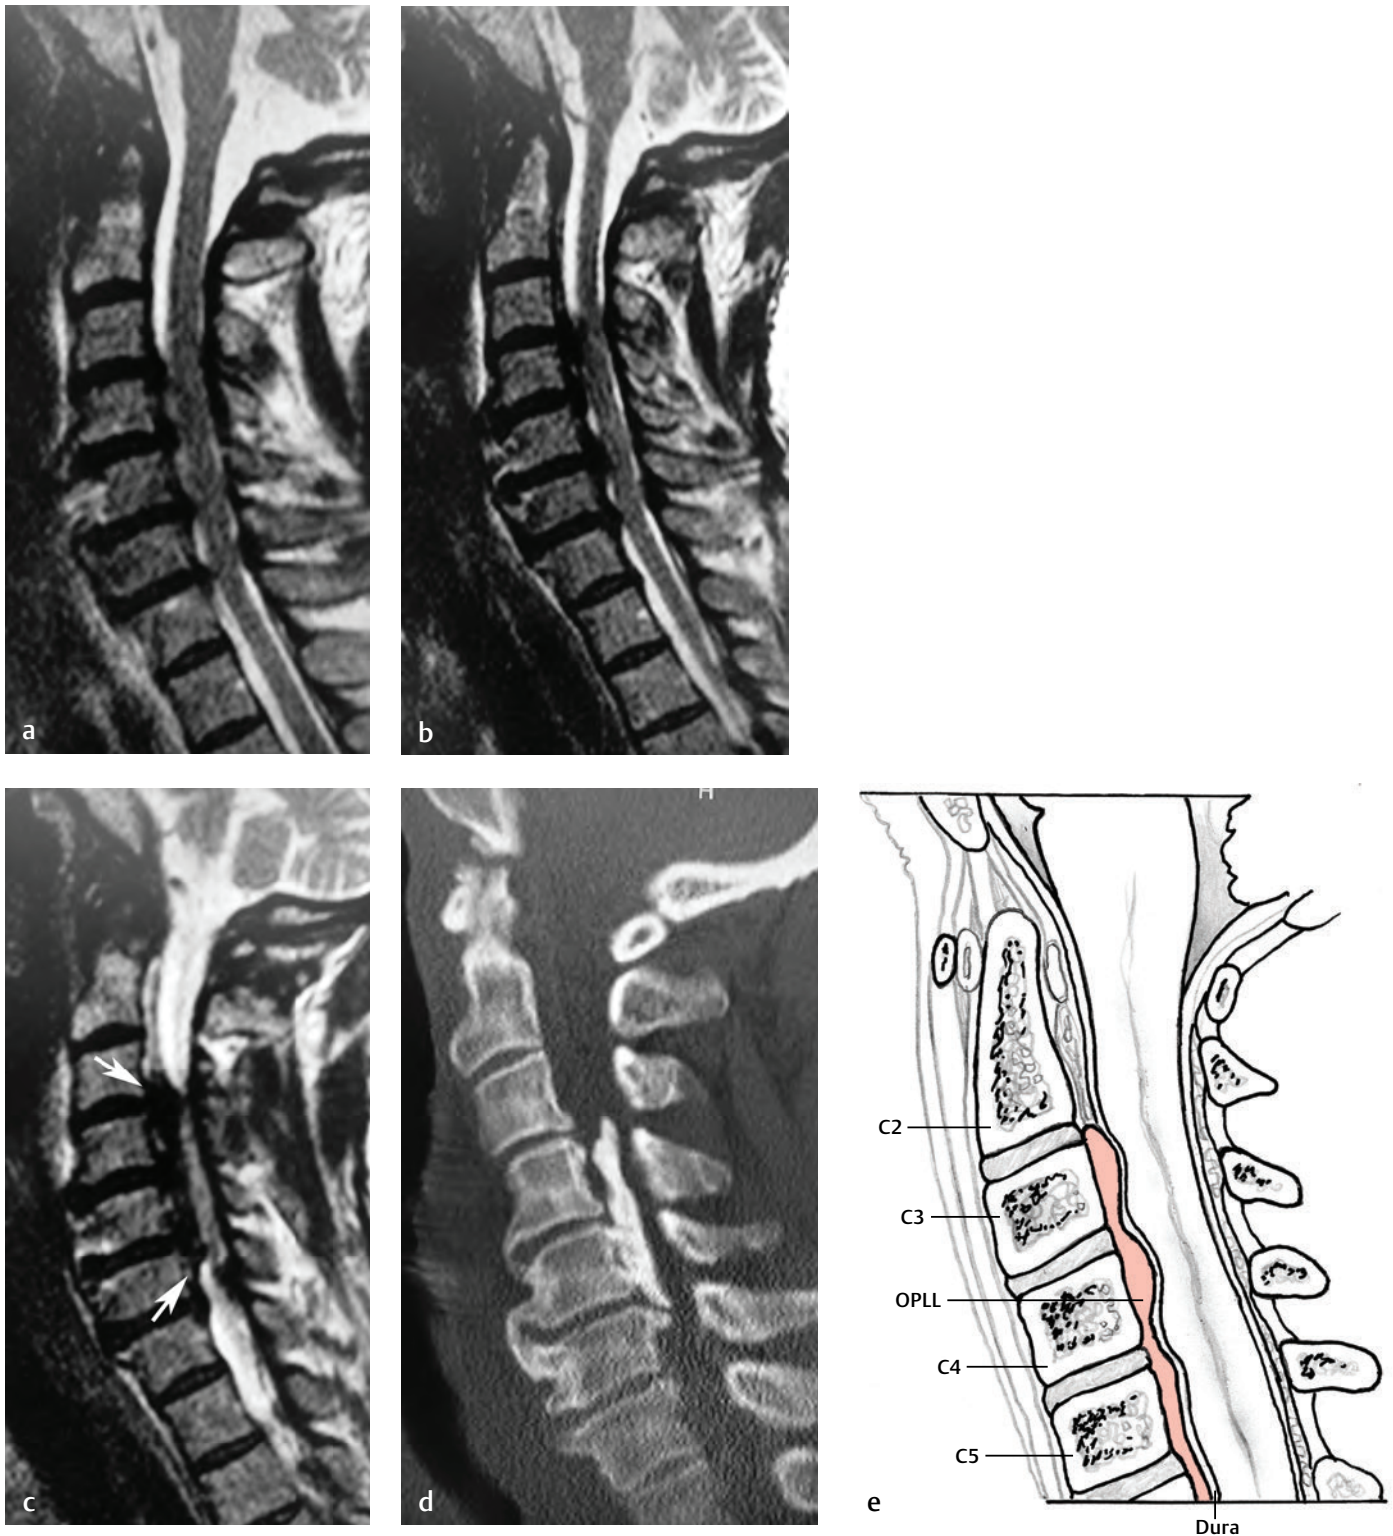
Ossification of the posterior longitudinal ligament (OPLL). (a) A midline sagittal T2-weighted image shows multilevel degenerative disc disease and moderate stenosis from C3-C4 to C6-C7. The stenosis appears to be centered at the level of the disc spaces on this midline image.[†] (b) A parasagittal T2-weighted image, obtained a few millimeters lateral to the midline, suggests that the posterior longitudinal ligament is thickened and that the stenosis is present at the level of the vertebral bodies and discs from C3 to C7.[†] (c) A parasagittal T2-weighted image, obtained farther from the midline, shows that the posterior longitudinal ligament is markedly hypertrophied and nearly fills the spinal canal (*between arrows*).[†] (d) A parasagittal reconstructed CT image, obtained at the same level as (c),[†] and (e), corresponding artist's sketch, show ossification of the posterior longitudinal ligament extending from C3-C4 to C5-C6.
